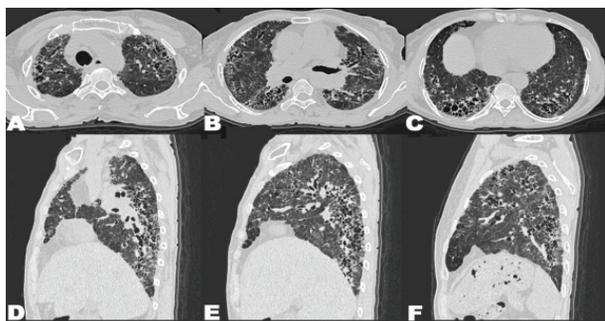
Axial CT images lung window (A, B, C) and sagittal images (D, E, F) showing irregular interlobular septal thickening, honeycombing with traction bronchiectatic changes. There is temporal heterogeneity and apico basal gradient (evident on sagittal images). Also note the interface sign (Irregular mediastinal borders) suggestive of fibrosis
